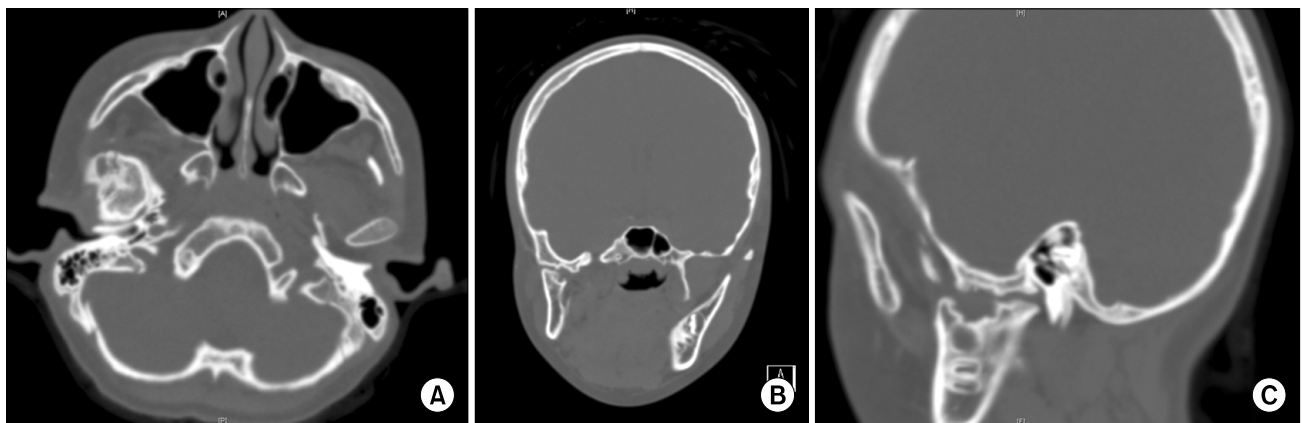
Preoperative axial, coronal, sagittal view and 3-dimensional reconstructed model on computed tomography. (A) Axial view, (B) coronal view, (C) sagittal view.
